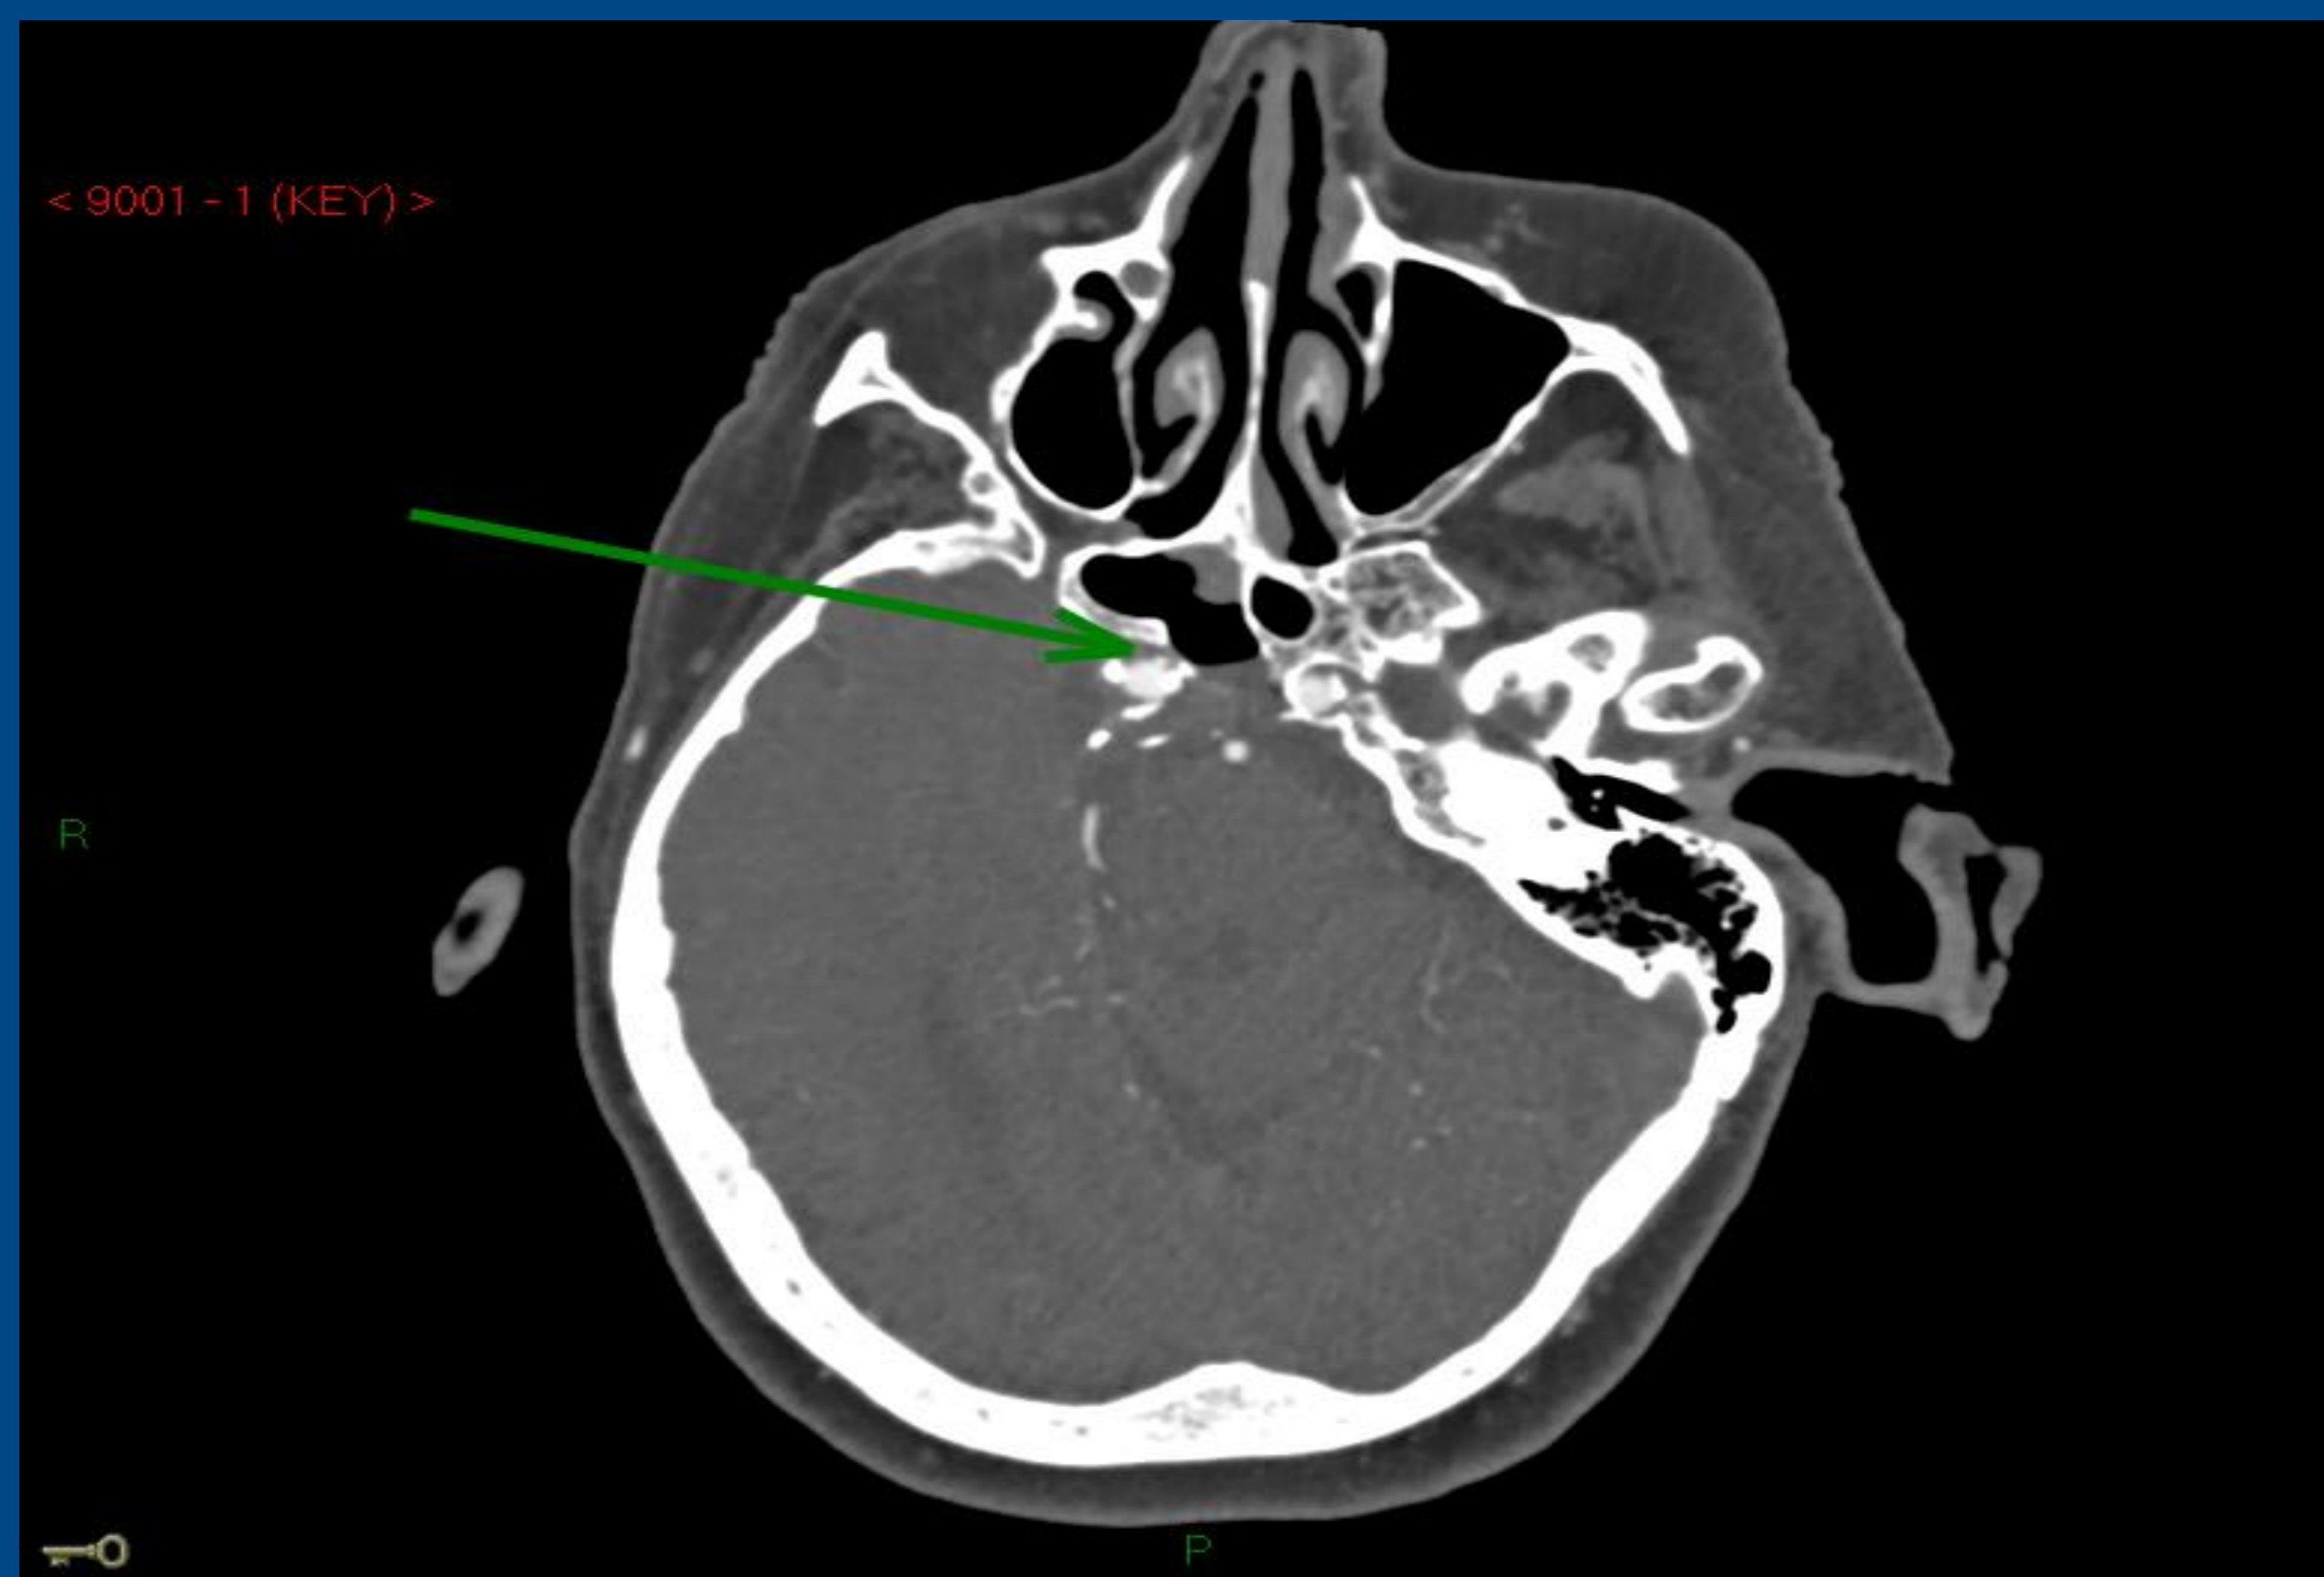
CT angiography- sphenoid necrosis and right ICA exposure
